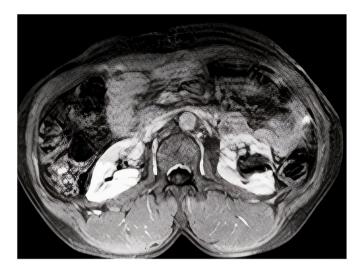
CT image showing right renal lesion.
